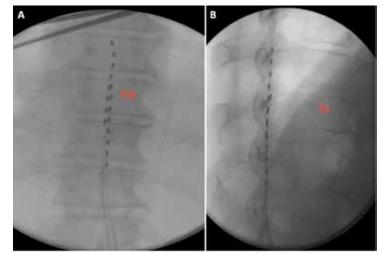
Anteroposterior (A) and lateral (B) radiograph view demonstrating lead placement at the top of T8 and T9 during the initial SCS placement in 2016.
